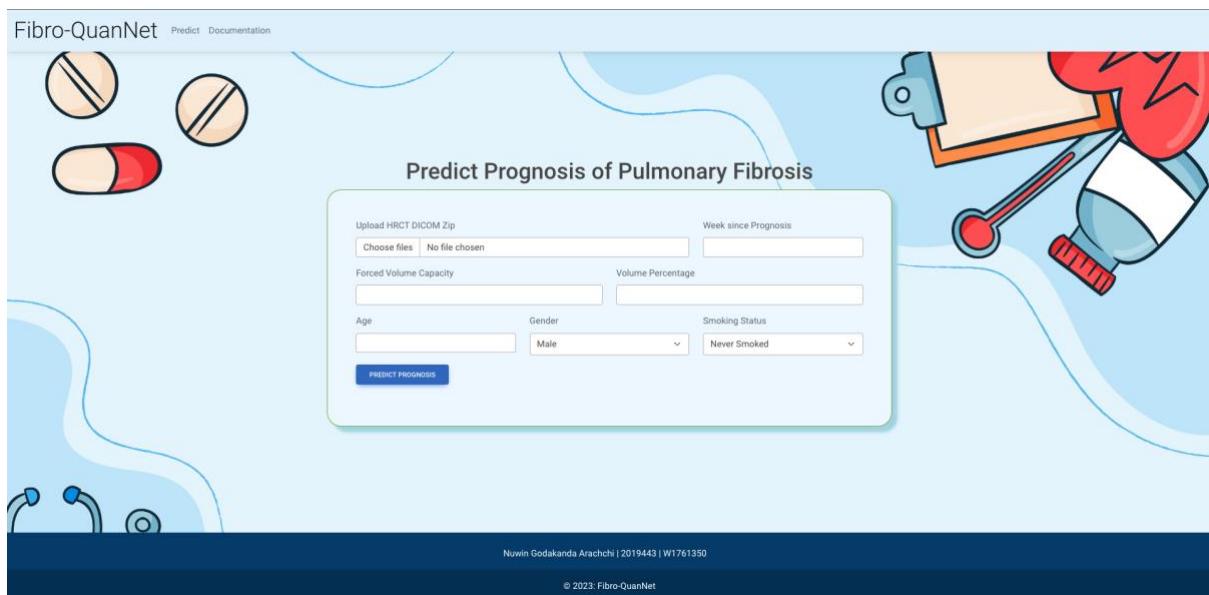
Upload HRCT Predict UI Screen
